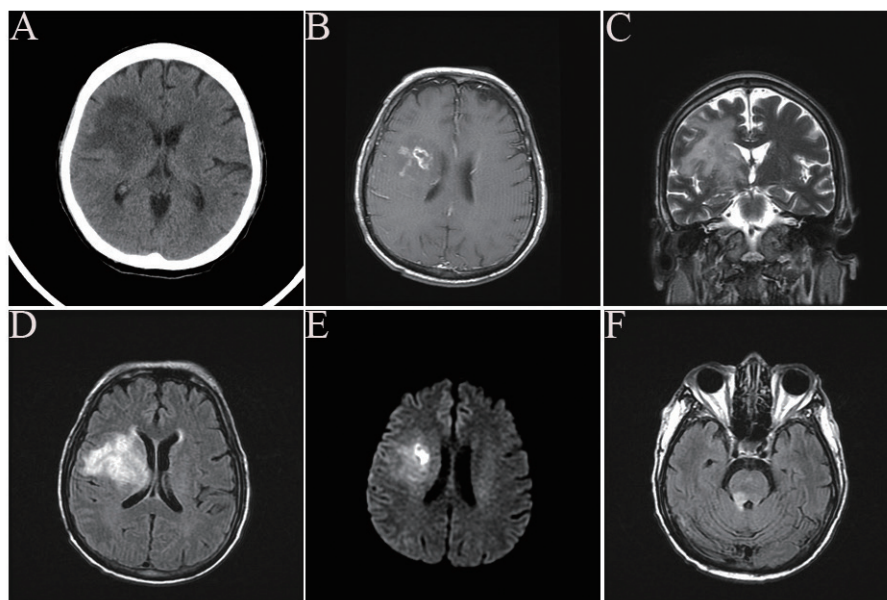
Non-contrast computed tomography scans reveal low attenuation in the right frontal region (1a). Furthermore, brain magnetic resonance imaging (MRI) reveals: brain edema with local mass effect in the right frontotemporal, basal ganglion, and periventricular white matter region on post-contrast T1-weighted images in the axial position (1b) and T2-weighted images in the coronal position (1c). Fluid-attenuated inversion recovery (1d) and diffusion-weighted imaging sequences (1e) confirm the edema lesions. A brain edema lesion is also noted in the midbrain and pontine areas on T2-weighted and fluid-attenuated inversion recovery images (1f).
